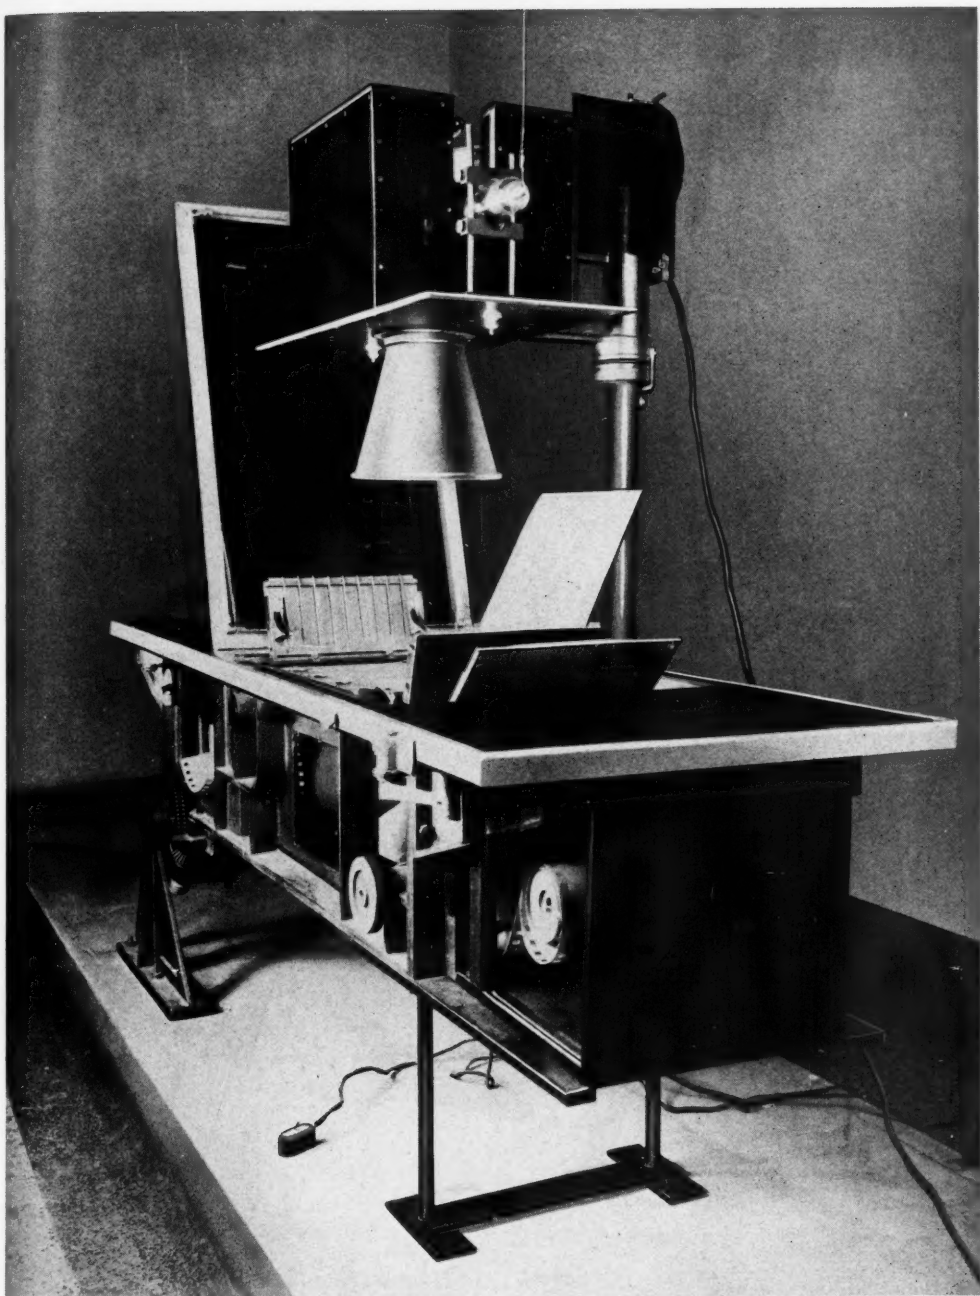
A roentgenocinematographic apparatus designed to move a perforated film 10 inches wide in exactly the same manner that a standard motion picture camera moves a smaller film. This apparatus is installed in the Joseph Purcell Memorial Laboratory at the Fifth Avenue Hospital, New York City. With this apparatus we are able to make true motion pictures of the stomach and a short run of a roentgenocinematographic film is shown in Figure 15.
